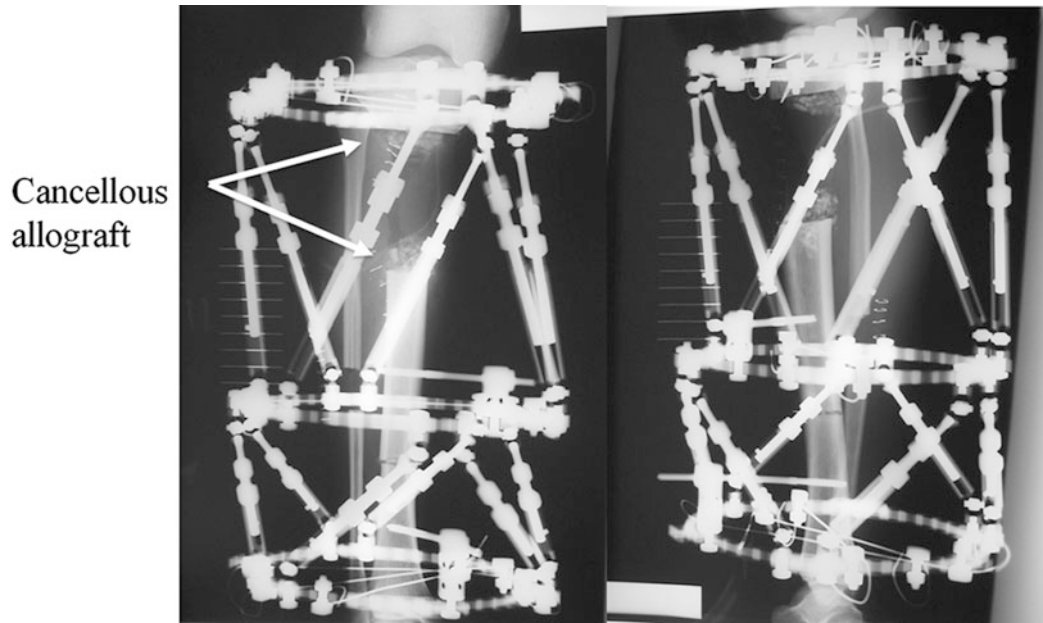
Radiographs recorded immediately after operation
